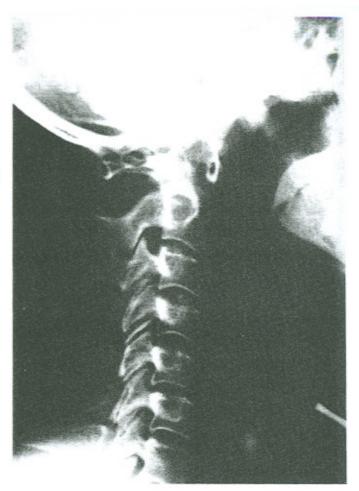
Lateral radiographs of the cervical spine in flexion and extension. Note in flexion the $\dot{A}DI$ is 8mm.
